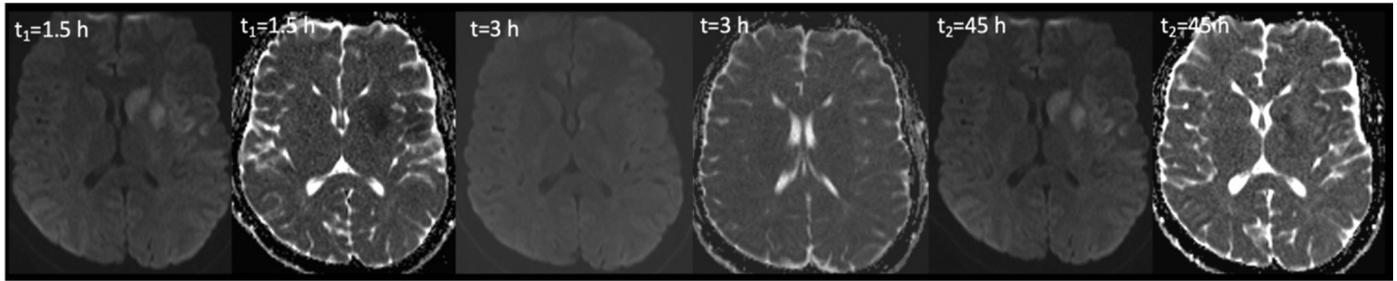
Aborted stroke: A previously healthy 32-year-old woman was admitted with acute onset right-sided hemiplegia and aphasia (admission NIHSS: 10; 24th-hour NIHSS: 3). Left-sided basal ganglia and insular infarction were observed in the DWI performed at the ninety minute after the onset of the event, lesions disappeared at the third-hour DWI, and the lesion reappeared at the end of the second day
